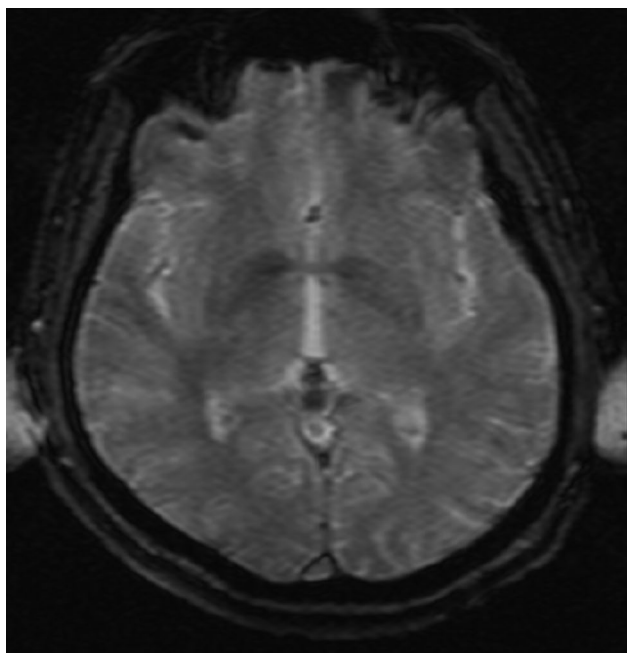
T2 weighted brain MRI scan
